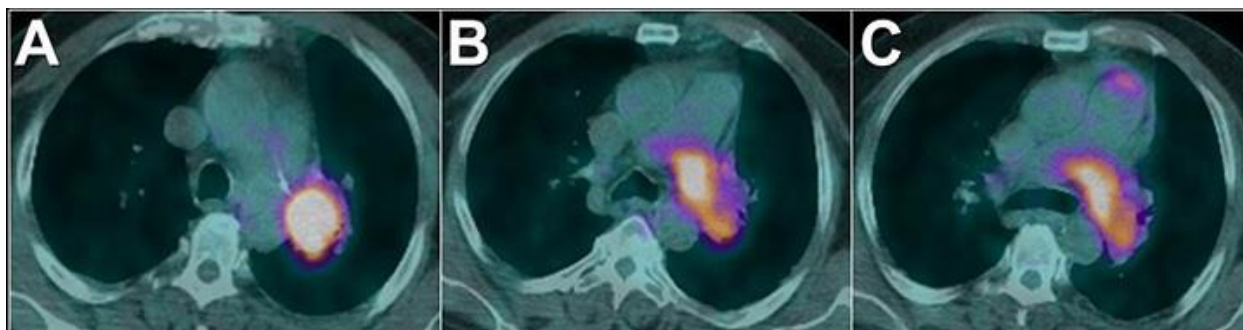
Axial FDG-PET images show intense hypermetabolic activity corresponding to the filling defect within the left pulmonary artery seen at contrast-enhanced thoracic CT.
